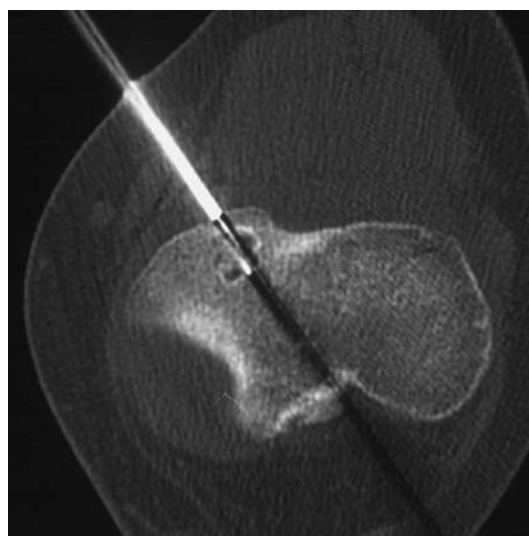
Axial CT demonstrating the position of the radiofrequency ablation needle in the lesion
